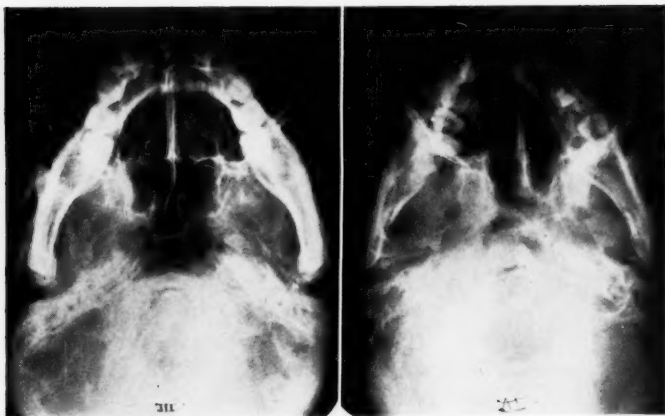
Roentgenograms of the skull made in the vertical position contrasting a normal skull (left) with the skull of a patient dying from an advanced transitional cell carcinoma which had invaded the floor of the middle fossa, the sella turcica and the posterior portions of the sphenoids.
